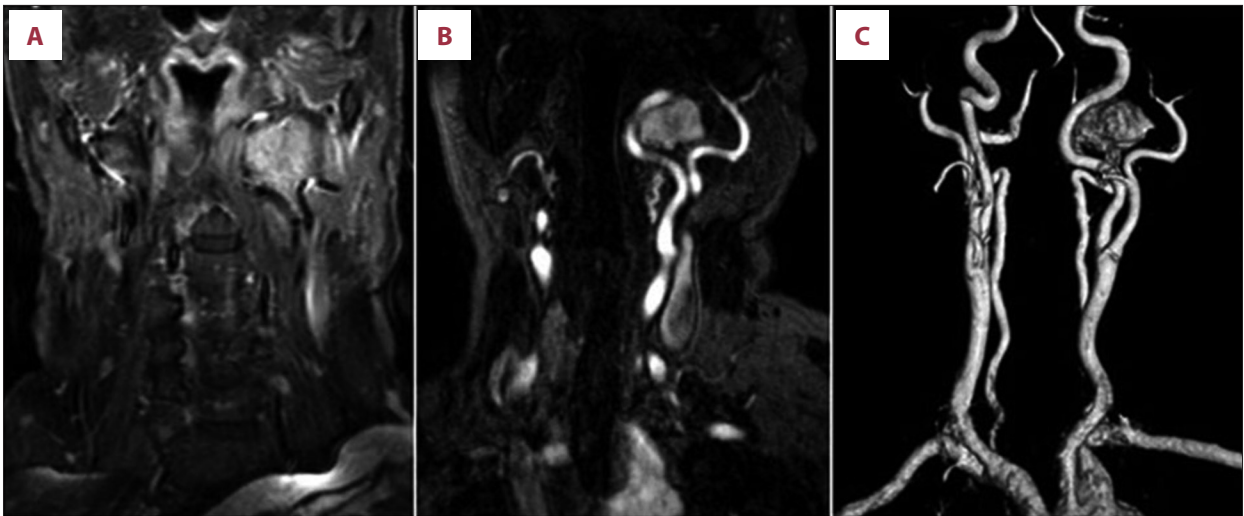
Coronal postcontrast T1-weighted images (A) shows increased contrast enhancement. Coronal multiplanar reformation (B) and maximum intensity projection (C) contrast-enhanced MR angiography images demonstrates lesion localized superior to the carotid bifurcation level, between left ICA and ECA. Lesion pushed left ICA to anterior and medial.
